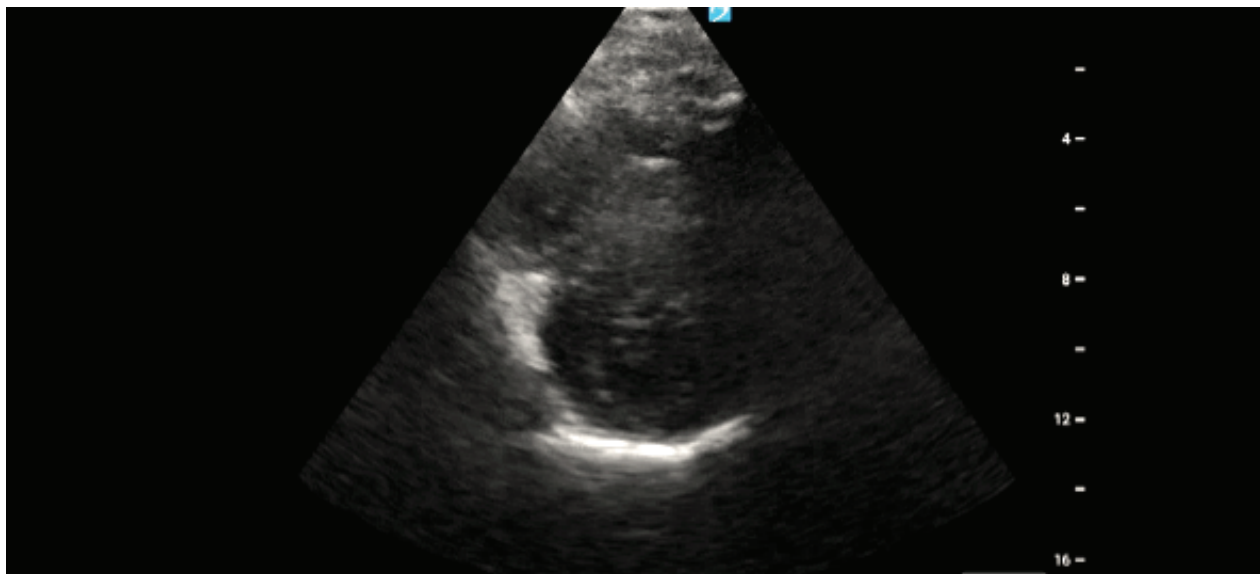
Parasternal Long Axis.
